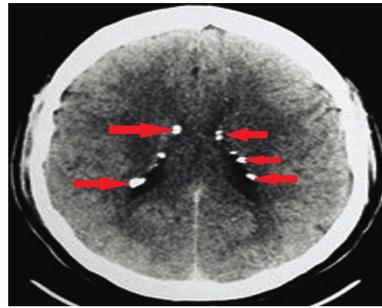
CT Brain of a 3 y old female revealing calcified lesions/sub-ependymal hamartomas seen along the lateral surface of the lateral ventricles giving rise to characteristic candle dripping appearance.
